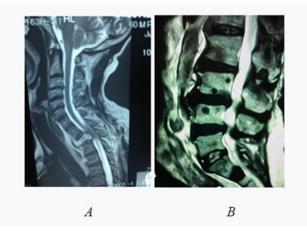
Magnetic resonance image of bone metastases of prostate cancer at the vertebral column and their effects. A: Spinal cord compression; B: Prostate cancer with bone metastasis.
